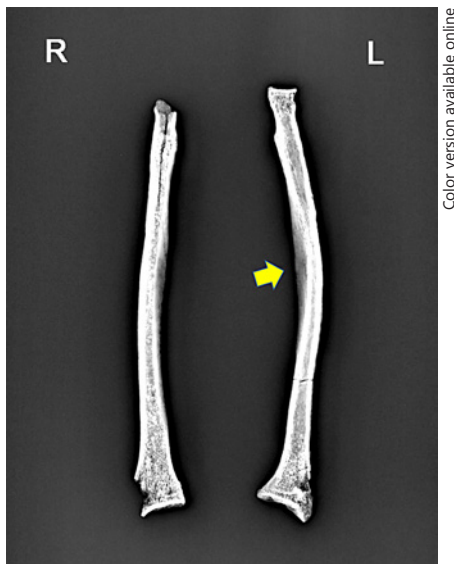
Radiograph of both radii. A-P projection. Bone remodeling (arrow).
